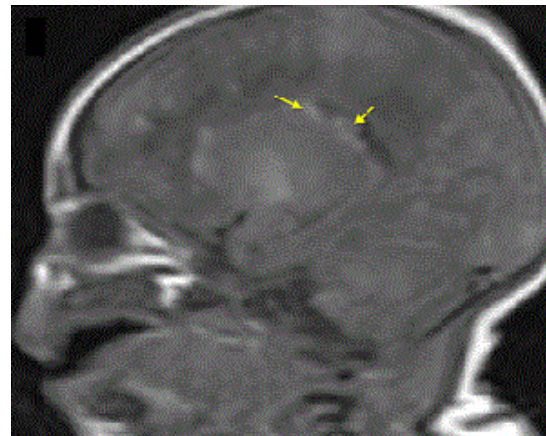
MRI showing sub-ependymal hematomas.
